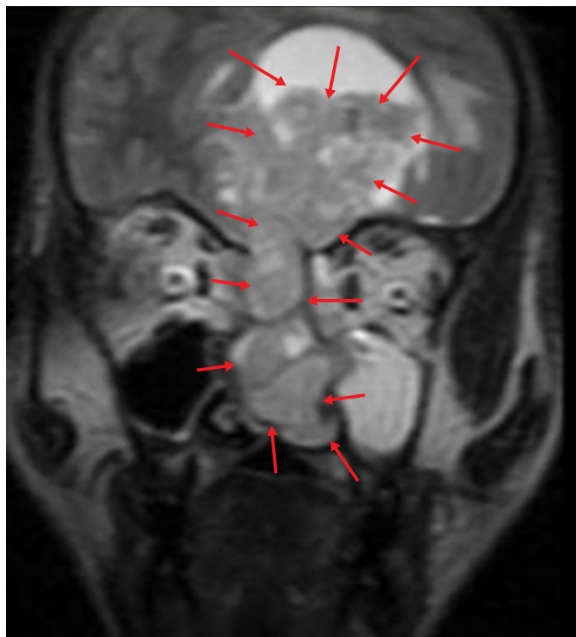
Coronal view of a CT scan of a patient with a massive neuroesthesioblastoma. The arrows outline the tumor, which has greatly distorted the normal nasal anatomy in this patient.
